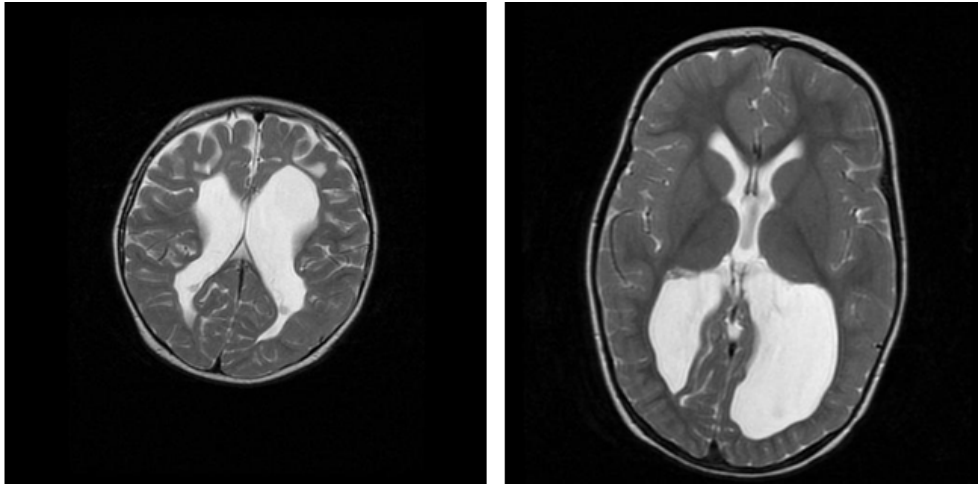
T2 brain MR images of children at the age of approximately two years which suffer from cerebral palsy. It can be observed that the reduced brain tissue is replaced with cerebrospinal fluid.
